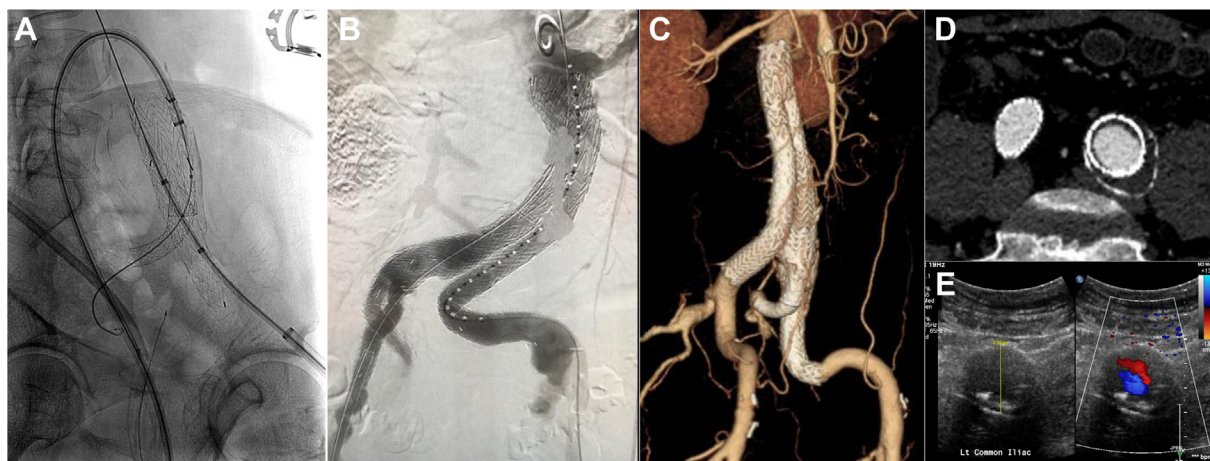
A, Intraoperative fluoroscopic image demonstrating deployment of the iliac branched device over a Rosen wire in a 62-year-old man with vascular Ehlers-Danlos syndrome (VEDS; *COL3A1*, c.555delT, p.Gly186-ValfsTer36, null variant). B, Intraoperative completion angiogram showing a satisfactory proximal seal and excellent blood flow into the preserved left internal iliac artery (IIA). C, Postprocessing three-dimensional image of a computed tomography angiogram 3 years postoperatively. D, Axial image of computed tomography angiogram demonstrating favorable common iliac artery (CIA) remodeling. E, Duplex ultrasound examination of the CIA 4 years postoperatively showing the same.
